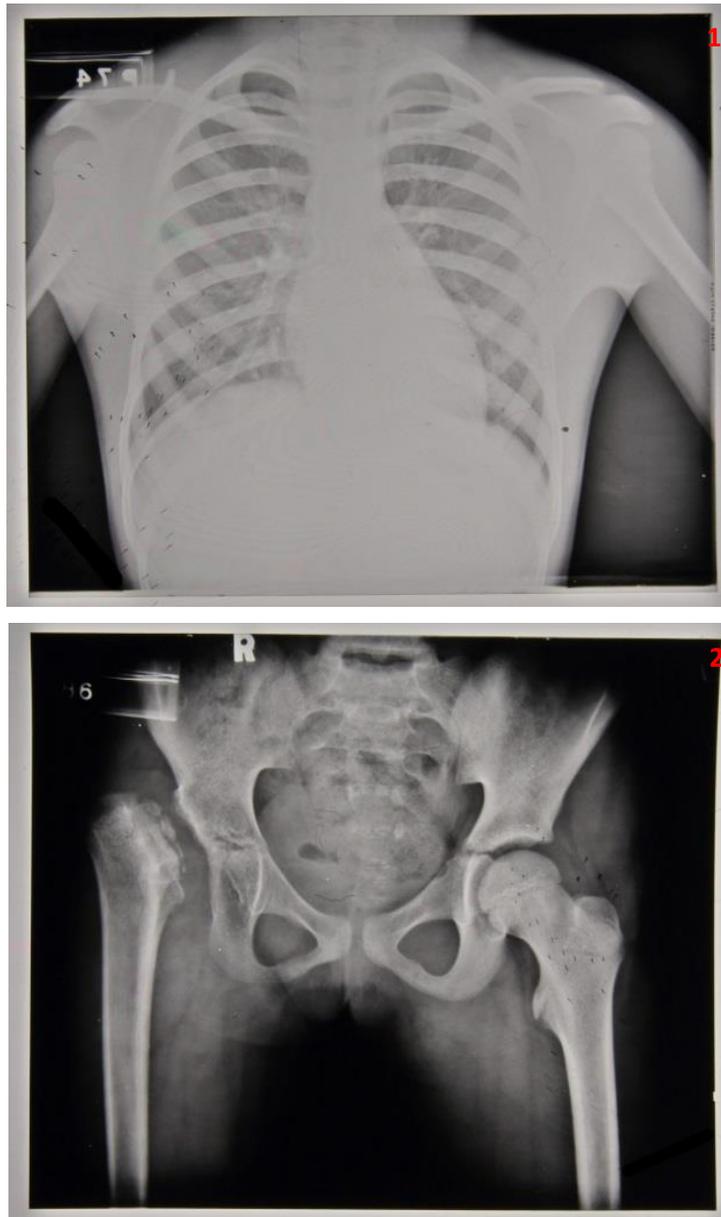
Radiographs from the Stannington Sanatorium collection (1934-1953). 1. Chest x-ray showing tuberculosis in the right lung. 2. TB in the right hip with destruction of the femoral head, neck and acetabulum (HOSP/STAN/7/1/2/132)
